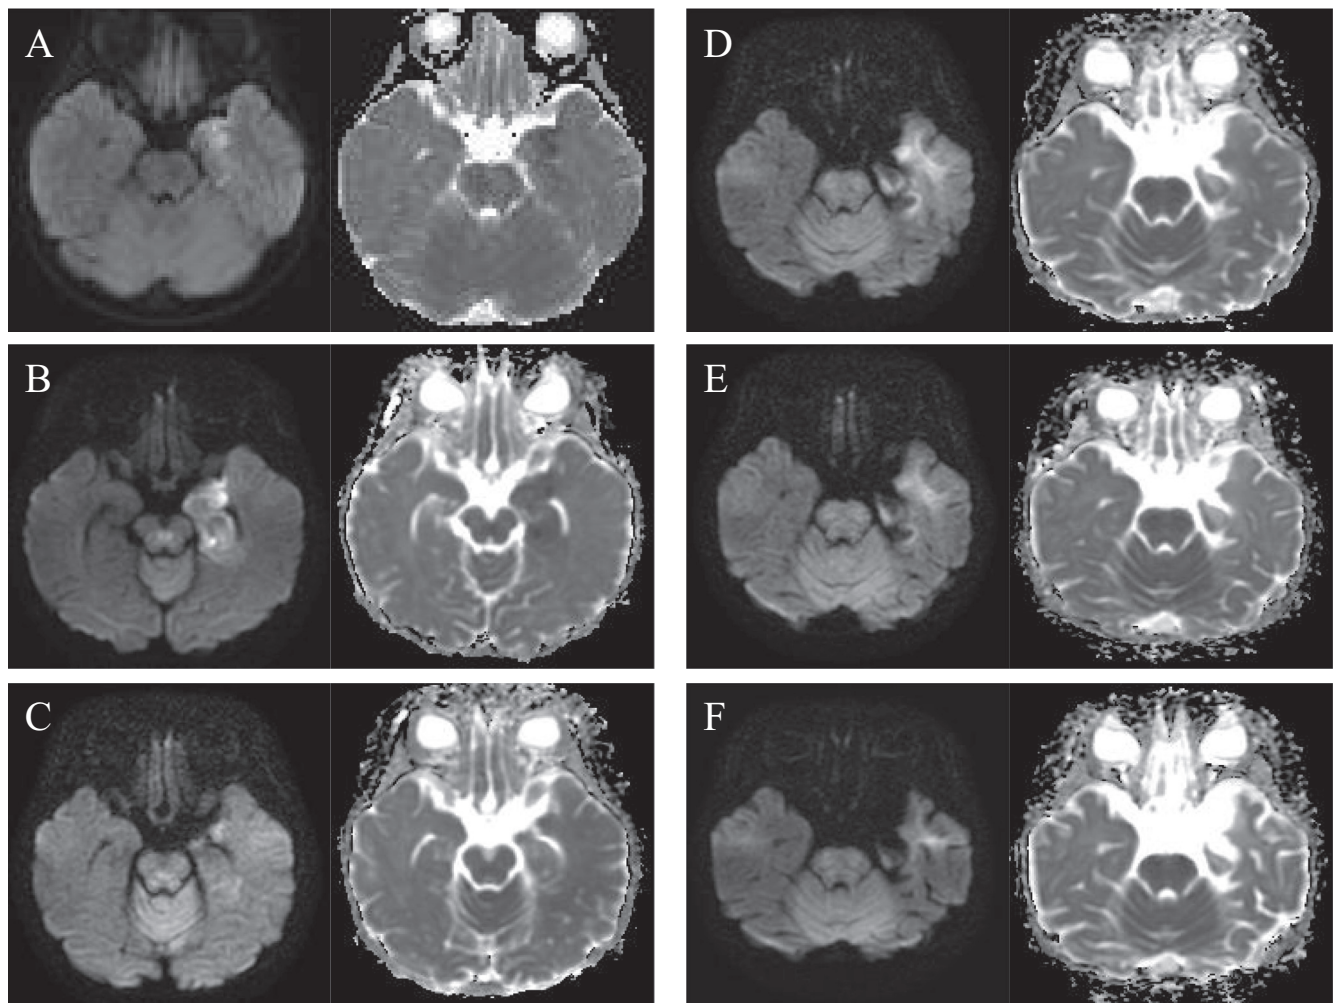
Magnetic resonance imaging on days 2 (A), 4 (B), 18 (C), 28 (D), 31 (E), and 46 (F) of admission. Diffusion-weighted image and apparent diffusion coefficient map are shown in each panel on the left and right sides, respectively.
